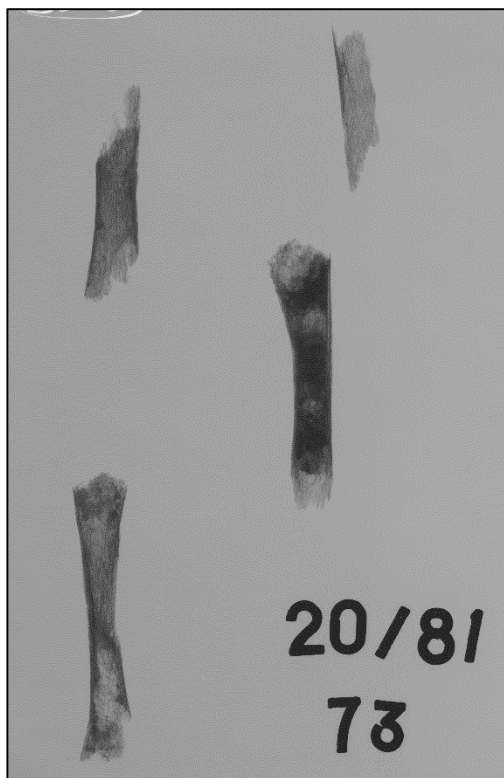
Possible thalassaemia as a differential diagnosis VI. Radiograph of the long bones of skeleton 73, 35 Kingsholm Road, displaying cortical thinning and enlarged trabeculae. (with permission from BARC)
